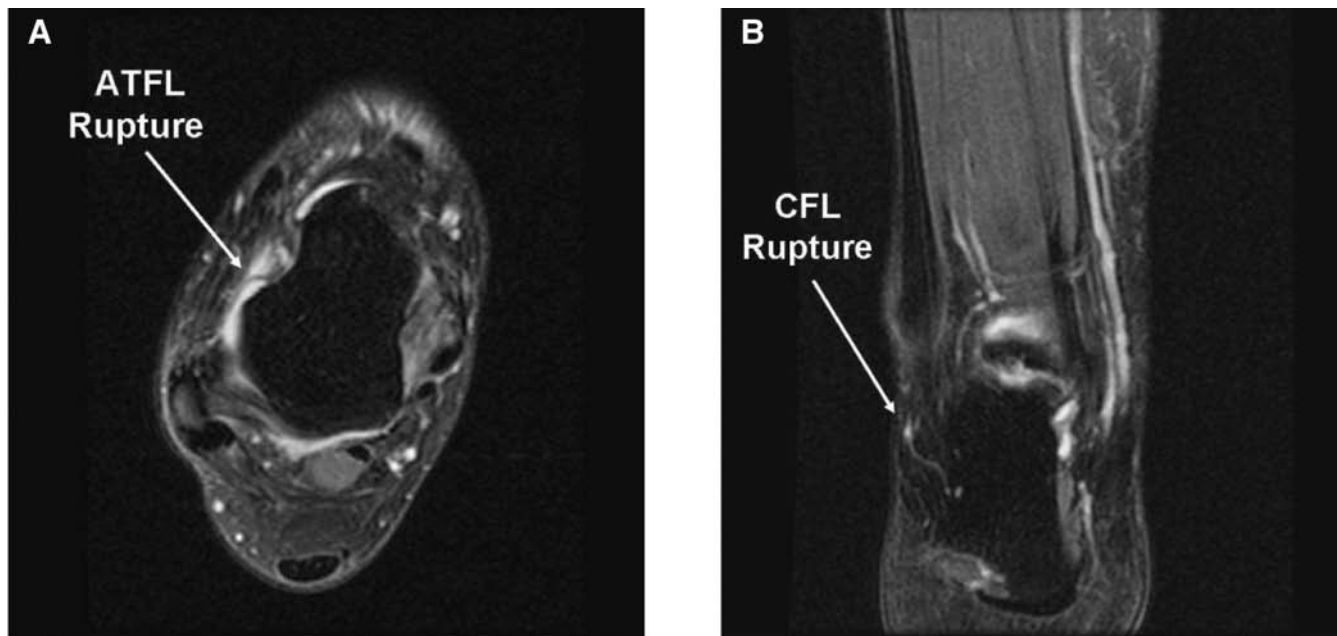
A, Magnetic resonance imaging scan showing anterior talofibular ligament (ATFL) rupture. B, Magnetic resonance imaging scan showing calcaneofibular ligament (CFL) rupture.
